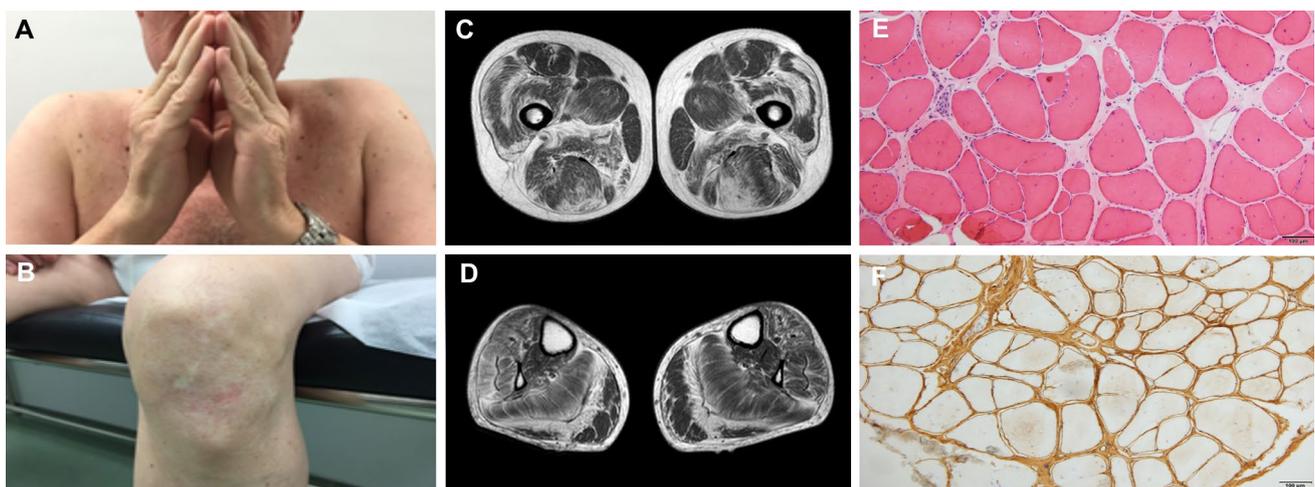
Characteristic interphalangeal contractures (a) and cigarette paper scars (b). Typical muscle MRI findings of Bethlem myopathy in T1-weighted sequence showing concentric involvement of *vastus lateralis* and central high signal in *rectus femoris* (c), as well as
